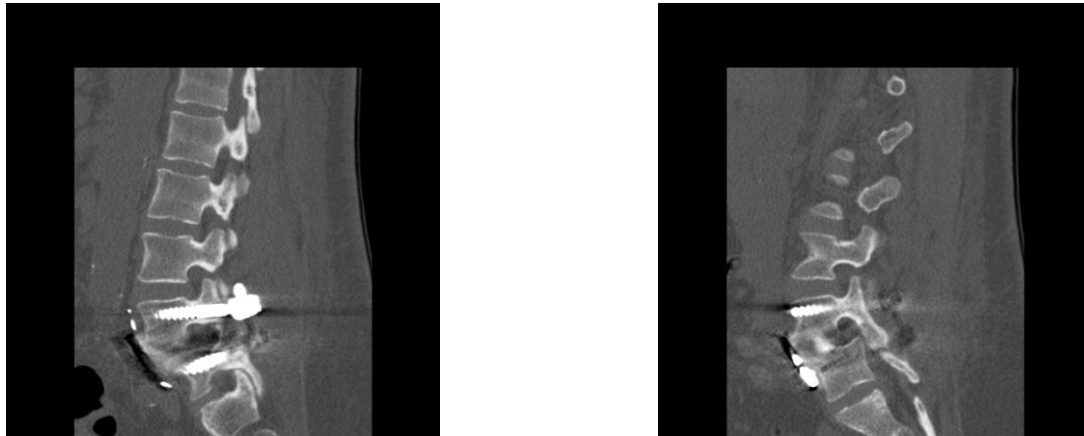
CT study at 7 months postoperatively showing solid anterior and posterior arthrodesis.
